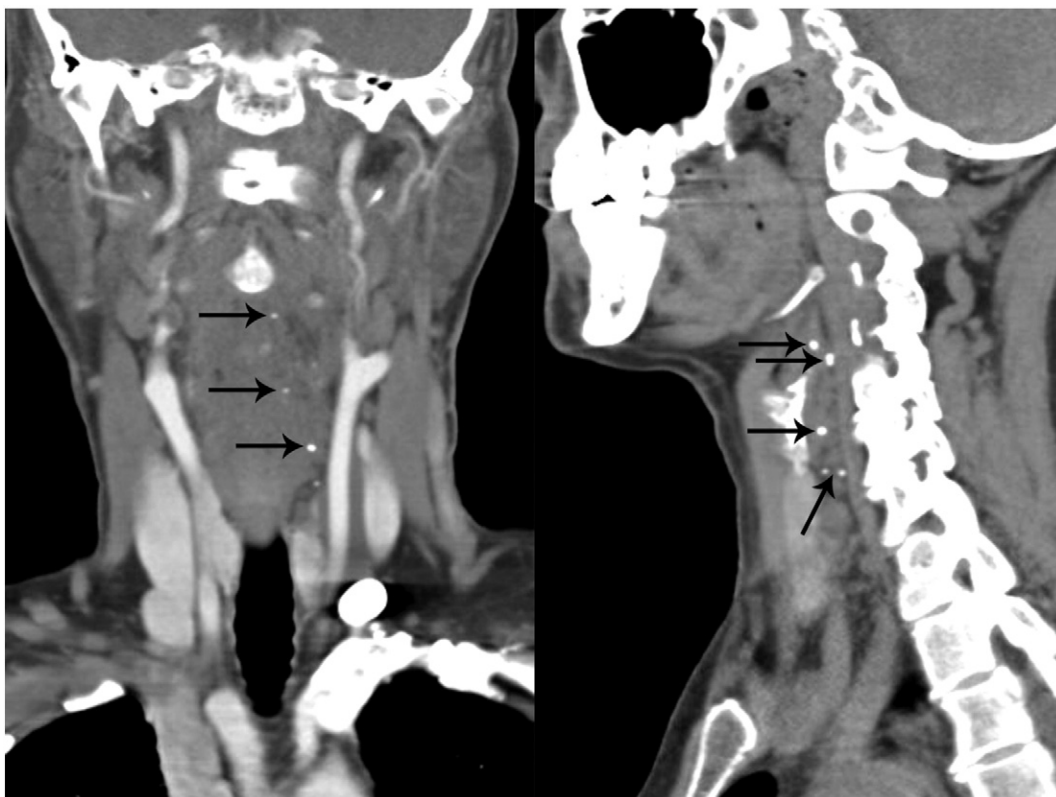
Coronal and sagittal contrast-enhanced CT images — multiple, small, round calcifications in the hypopharynx and left carotid sheath, consistent with phleboliths and strongly suggestive of a low-flow venous malformation.
